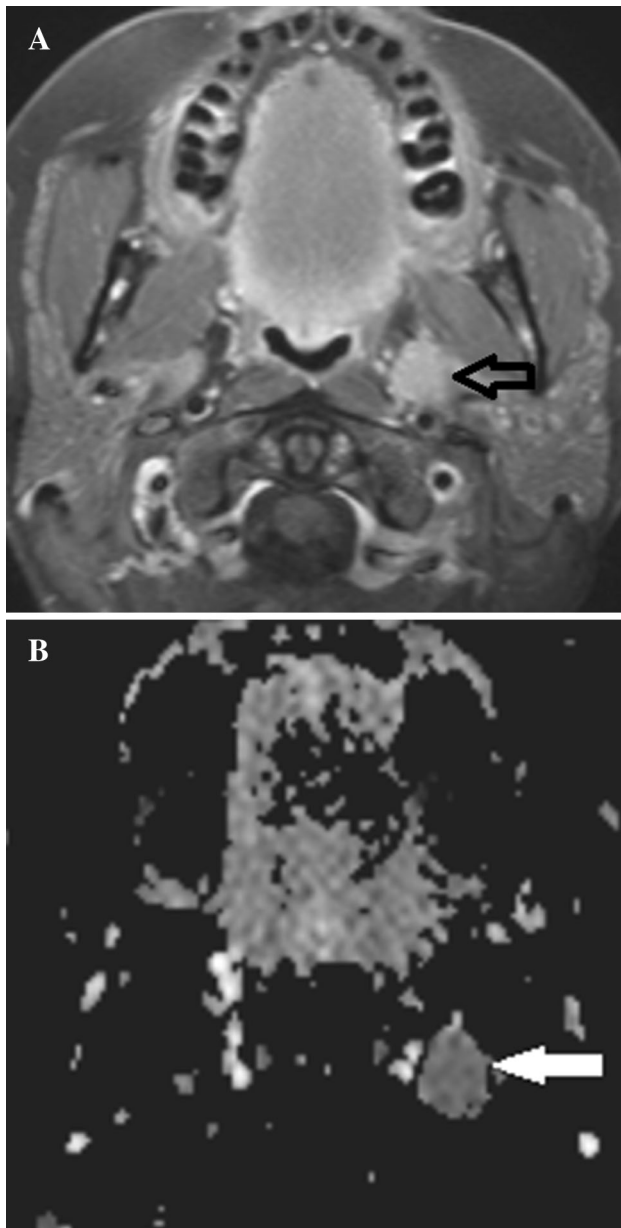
(a) Postgadolinium T1-weighted image of a 45-year-old female shows a well-defined enhancing mass in the left parapharyngeal space (*arrow*). (b) The increased signal observed in the corresponding ADC map is indicative of increased ADC values in the mass, which is suggestive of a benign process. This proved to be a benign pleomorphic adenoma
